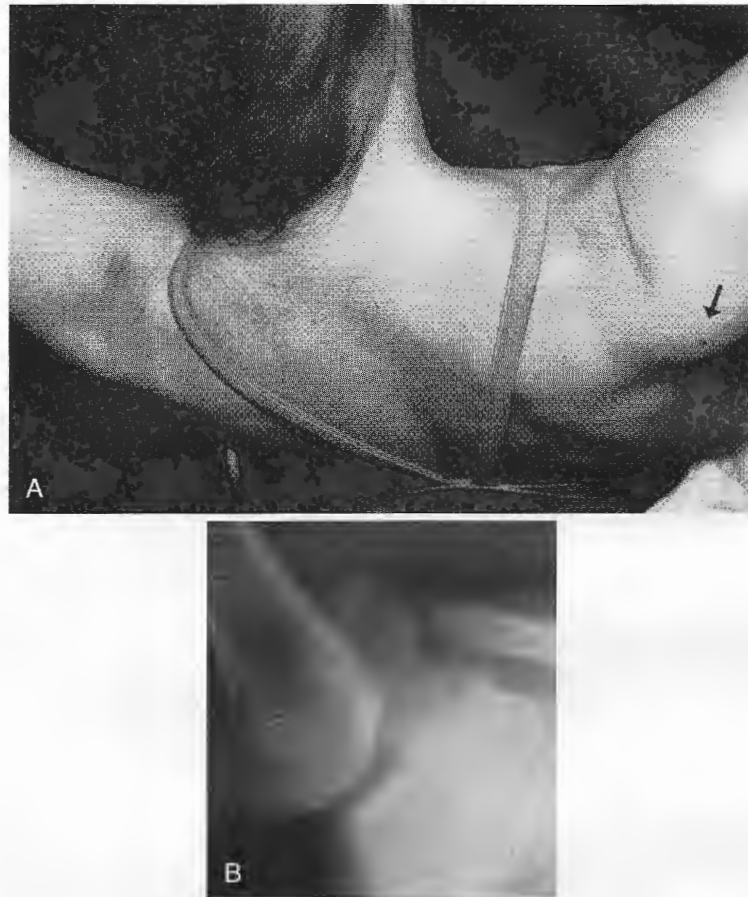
A, Posterior dislocation, habitual, of the right shoulder in this synchronized swimmer. Note the prominence of the humeral head (*arrow*). Athlete has self-dislocated her shoulder with her arm in internal rotation and forward flexion, 100 deg abduction. B, Radiograph with the shoulder posteriorly dislocated, osteophyte coming off of the inferior aspect of the glenoid, probable reverse Hill-Sachs' lesion and empty glenoid sign.
